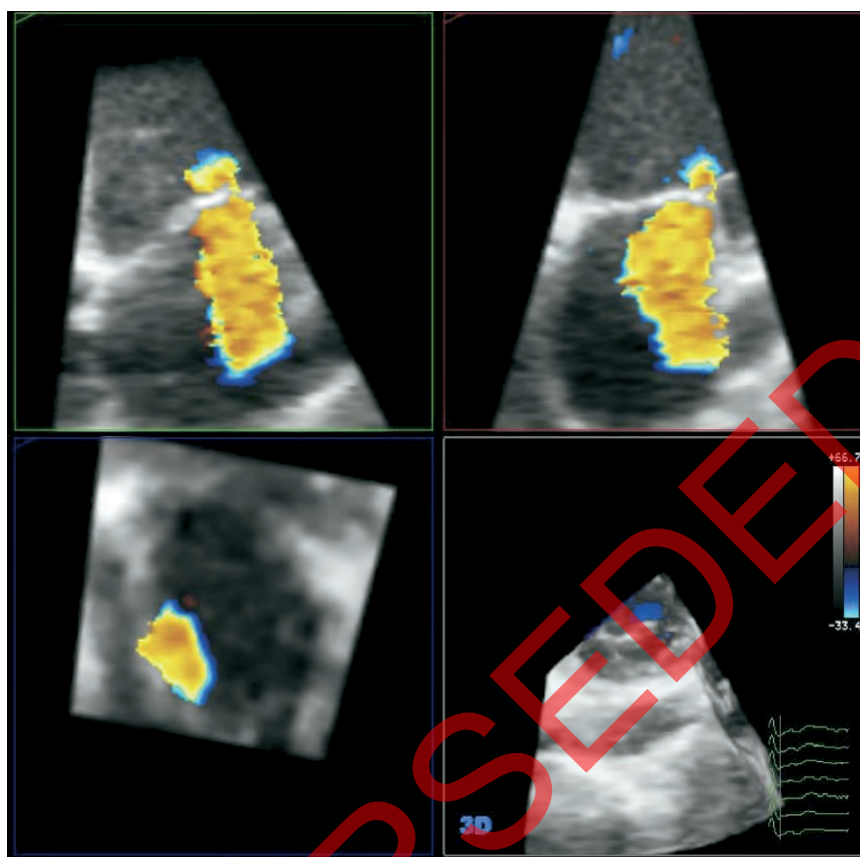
A 3D color Doppler display of mitral regurgitation.
